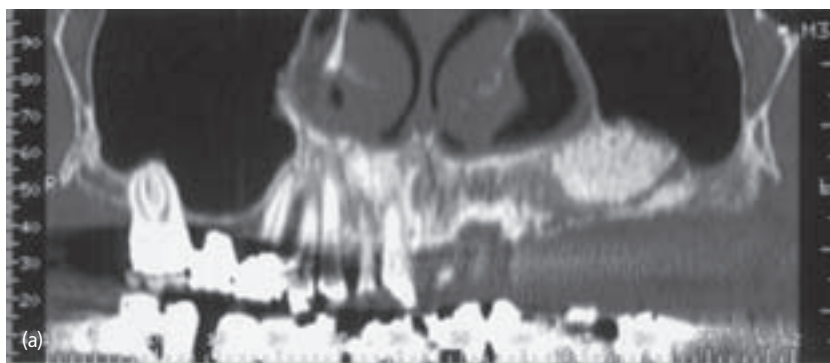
(a) Six-month postoperative panoramic CT (left side). (b) Six-month postoperative cross-sectional CT.
